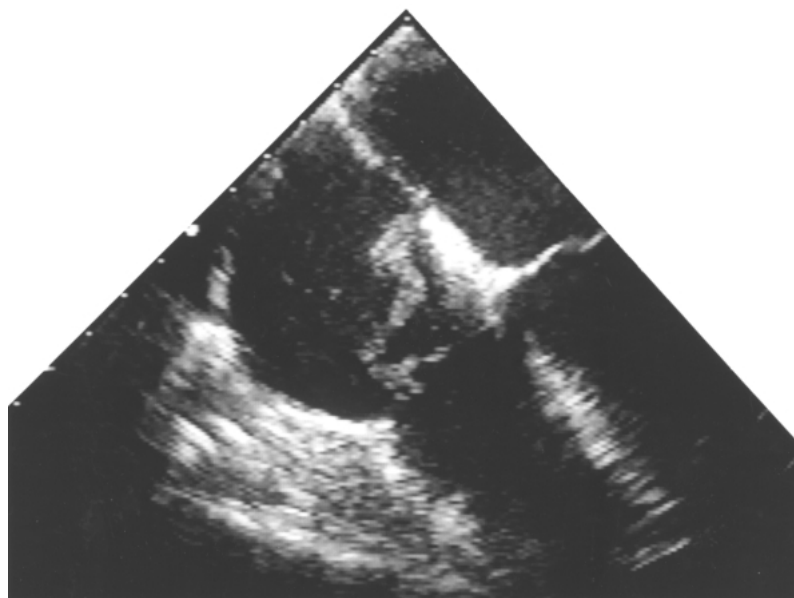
Transesophageal echocardiograph of the case patient on hospital day 1. A large, serpiginous thrombus is noted in the right atrium, lateral to the intra-atrial septum and superior to the septal leaflet of the tricuspid valve.
